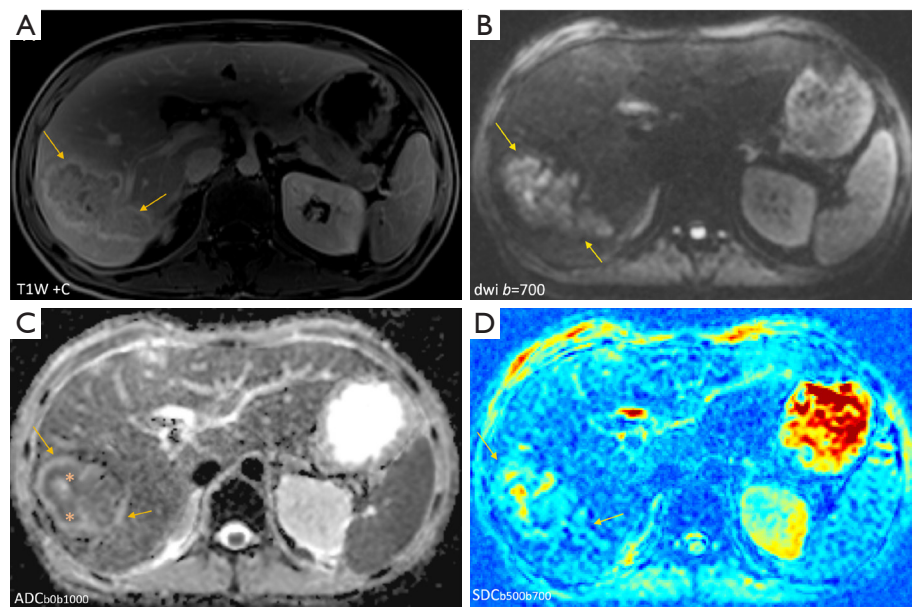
A 37-year-old diabetes mellitus man with a liver pyogenic abscess. (A) is post-gadolinium T1-weighted (T1W + C) image, a liver abscess is seen with peripheral rim (arrows). (B) is DWI of b value = 700 s/mm^2 , with the abscess showing high signal (arrows). (C) is ADC map (with b values of 0 and 1,000 s/mm^2), the abscess (arrows) had internal content with mixed signals and some areas showing slightly lower value (asterisks) than that of the adjacent liver parenchyma. The peripheral rim of the abscess has higher ADC, which is a sign for abscess as described by Park *et al.* (11). (D) is SDC map (with b values of 500 and 700 s/mm^2), the abscess (arrows) had internal content with mixed higher signals than that of the adjacent liver parenchyma. Note that, as shown in (C), ADC of the spleen is notably lower than ADC of the liver parenchyma. On (D), SDC of the spleen is faintly higher than SDC of the liver parenchyma, and the overall SDC of the abscess is higher than SDC of the spleen. Overall, SDC map of this case suffers from low signal-to-noise ratio. ADC, apparent diffusion coefficient; DWI, diffusion-weighted imaging; SDC, slow diffusion coefficient.
